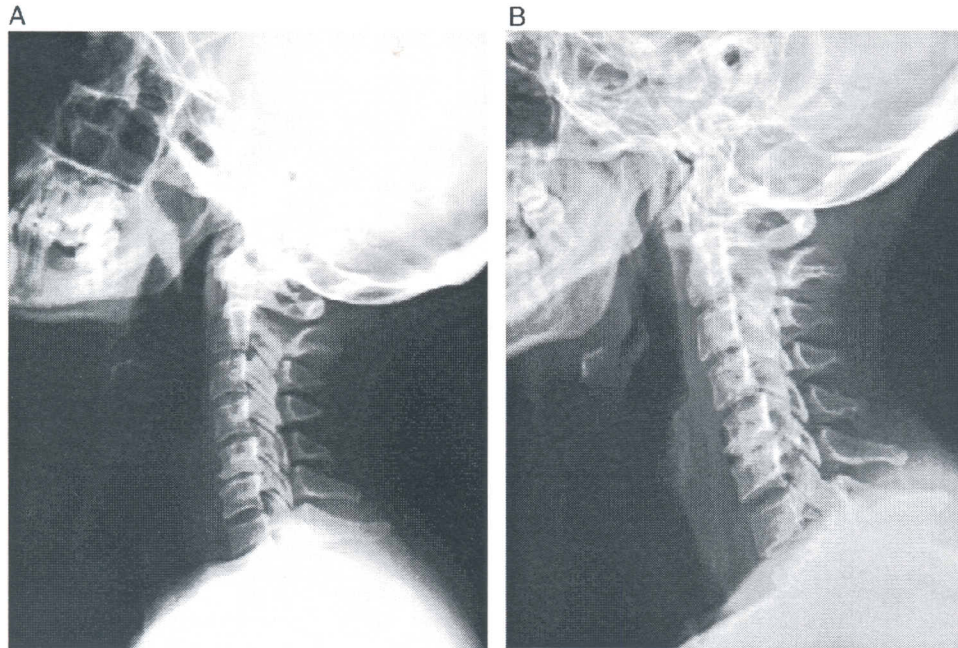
Preoperative (A) and postoperative (B) plain x-rays of a middle-aged woman with a C₅-C₆ lesion. Appropriate segmental realignment is obtained immediately after surgery.
